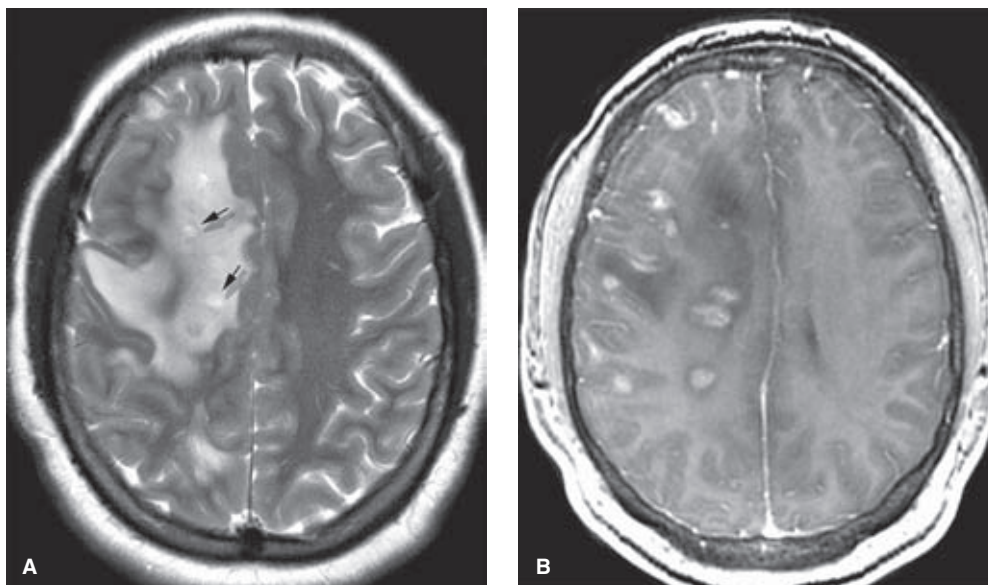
(A–C) Biopsy-proven PACNS. A teenaged female patient presented with recurrent seizure. T2-weighted MRI (A) showed extensive white matter confluent changes with unusual internal ring-like lesions (arrows in A), which demonstrated focal enhancement after administration of gadolinium (arrows in B). (continued)
